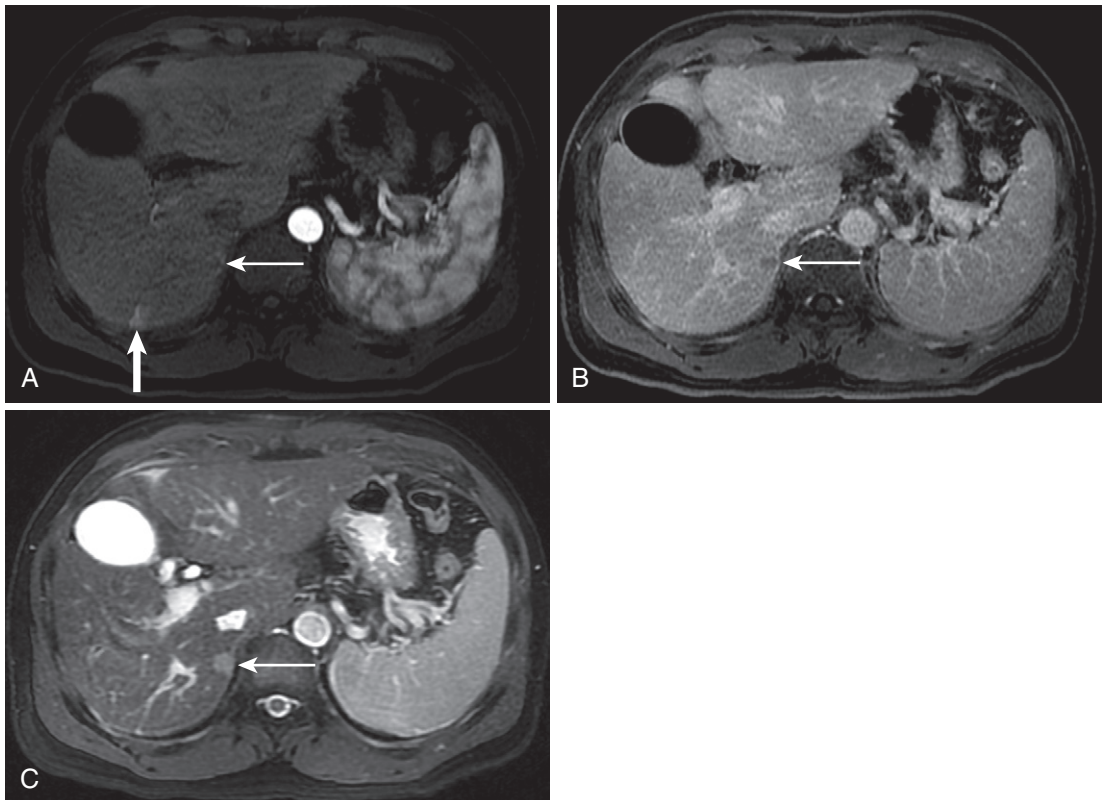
Small HCC. A, The arterial phase image shows a heterogeneously enhancing lesion in the medial aspect of the posterior segment (*thin arrow*) and a homogeneously enhancing lesion in the posterior aspect to the posterior segment (*thick arrow*). B, On the delayed image, the medial lesion washes out (*arrow*) betraying its malignant etiology—HCC—whereas the posterior lesion has faded, characteristic of a THID or benign vascular shunt. C, Note the HCC hyperintensity (*arrow*) on the T2-weighted steady-state image.
